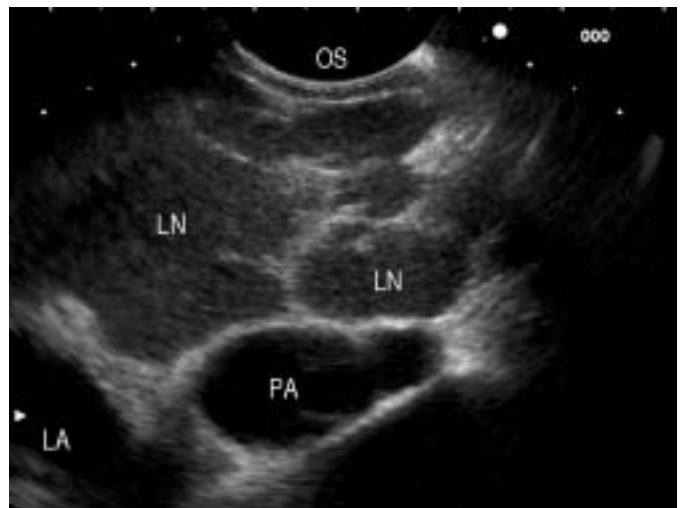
Endoscopic ultrasound image in a patient with sarcoidosis demonstrating multiple, well demarcated lymph nodes (LN) located between the oesophagus (OS), left atrium (LA) and pulmonary artery (PA).
